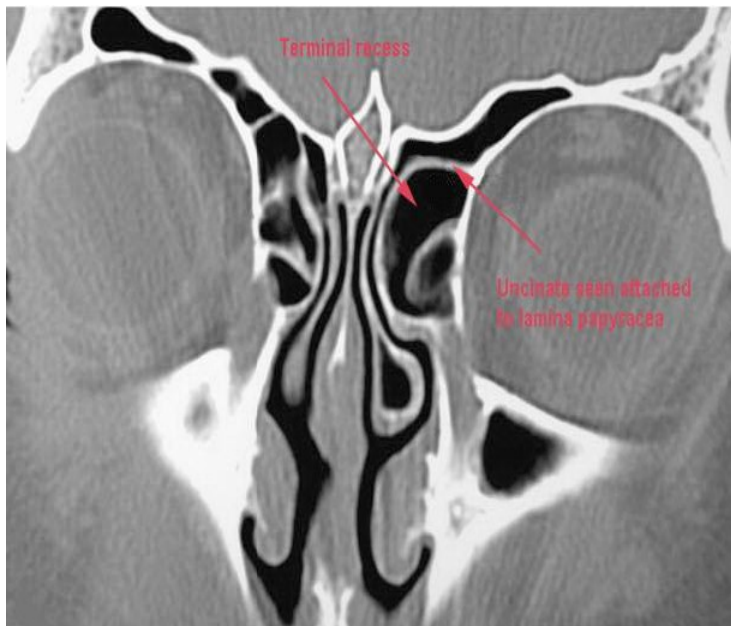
Coronal CT scan showing uncinata process being attached to lamina papyracea. This causes terminal recess to form. Frontal sinus drains directly into middle meatus
